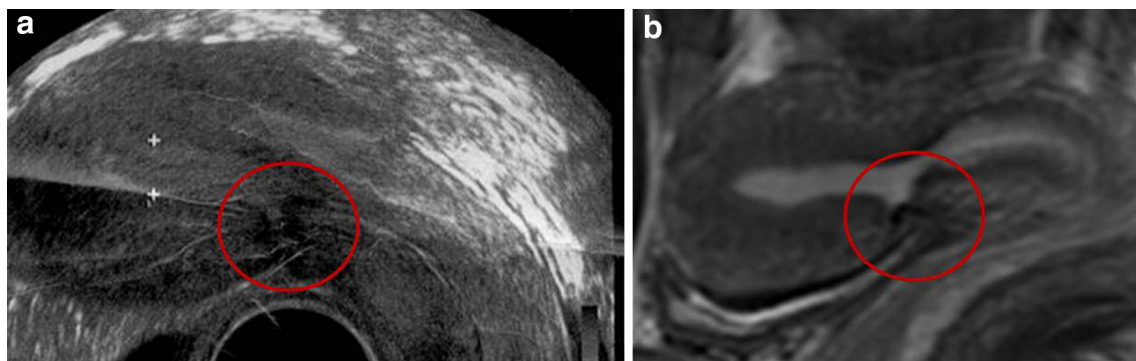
33-year-old woman with double caesarean delivery. a TVUS image of caesarean scar classified as retracting. b Para-sagittal T2 Ssh-TSE MR image of the same scar classified as retracting
